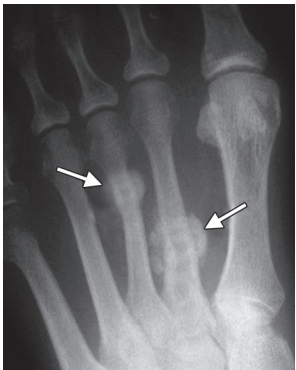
X-ray: Stress fracture
